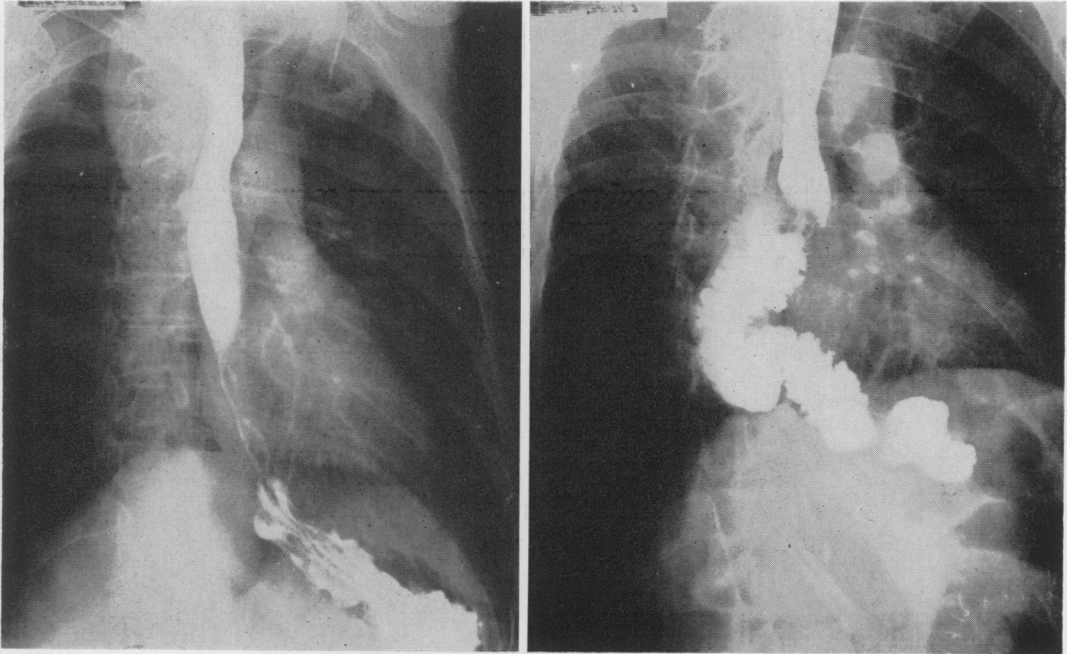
(A. H., Case 1.) Roentgenologic studies taken before and after sphincter substitution by an interposed jejunal segment.
